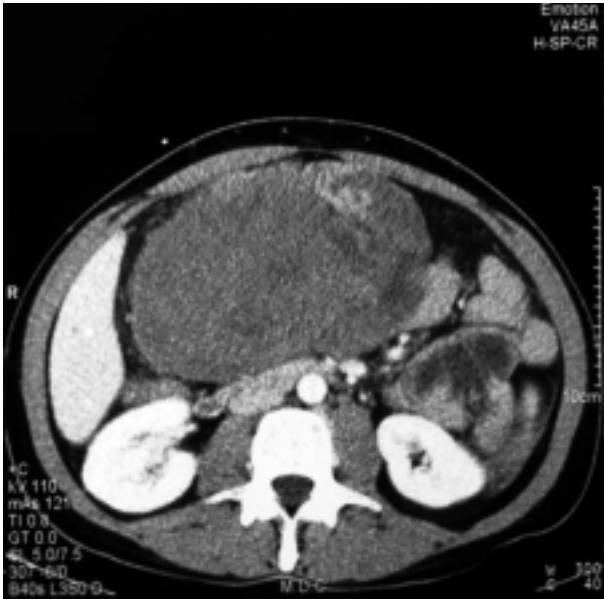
CT showing the intraperitoneal mass with disomogenic structure with peripheral contrast enhancement more expressed in the left portion of the mass
